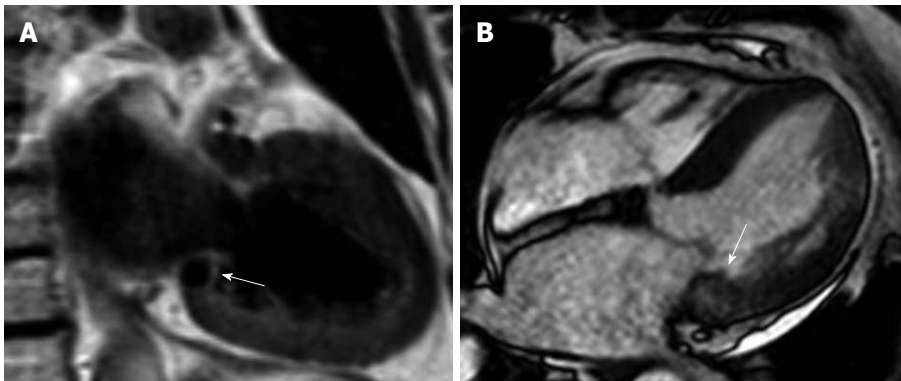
Cardiac magnetic resonance images (Philips 1.5 Tesla MRI scanner). A: A well defined dark mass (arrow) is near the posterior mitral valve leaflet in a T1 weighted sequence, suggestive of calcification; B: In steady state free precession images, the mass (arrow) appears only slightly darker than the normal myocardium, with a well defined intramyocardial border.
